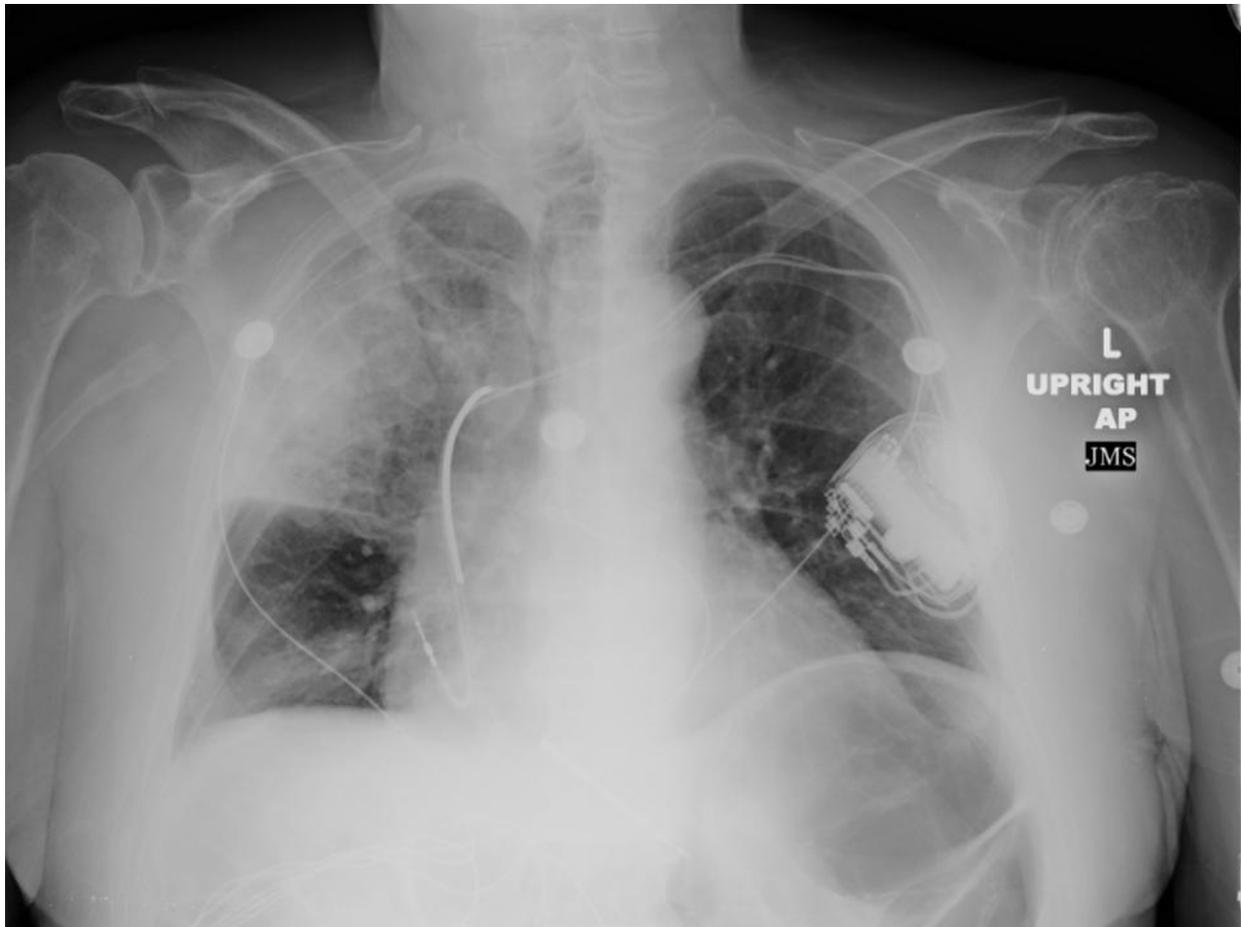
Admission radiograph demonstrating right upper lobe airspace disease.
